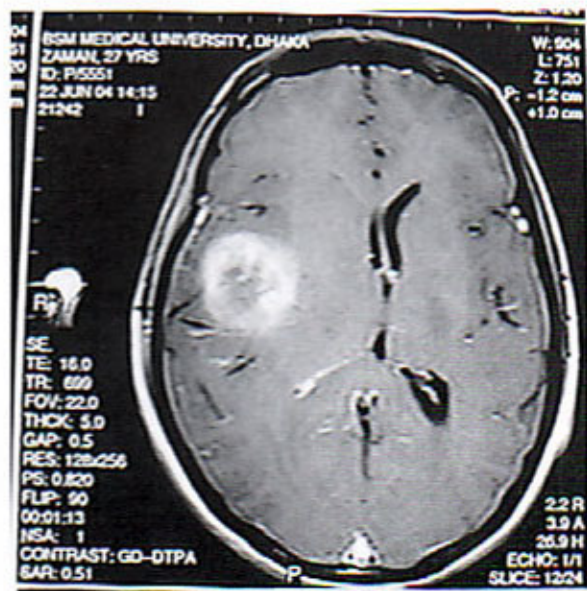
MRI axial view with contrast showing intracranial astrocytoma
